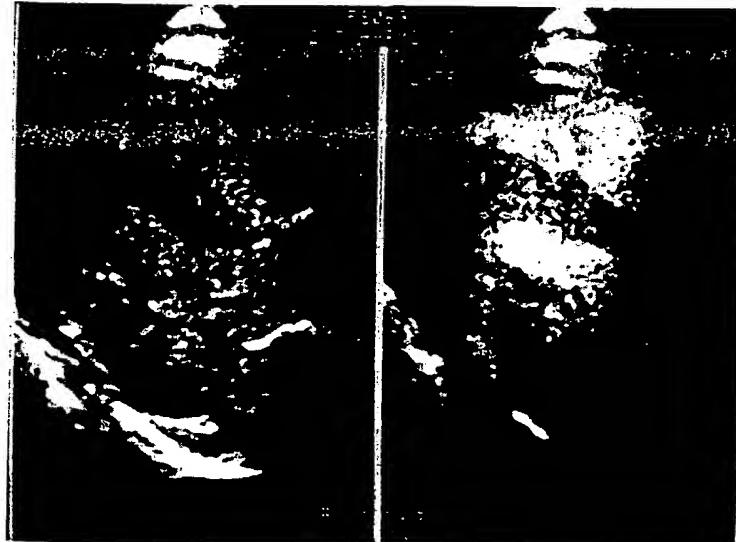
Myocardial opacification early (left) and late (right) after a 1 ml injection of Optison during continuous harmonic imaging. Parasternal long axis and apical four chamber views are shown. Early after the injection of Optison, right and left ventricular cavities are opacified but no myocardial opacification is seen. Late after the injection, good myocardial opacification is demonstrated (score of 3 on visual analysis).
